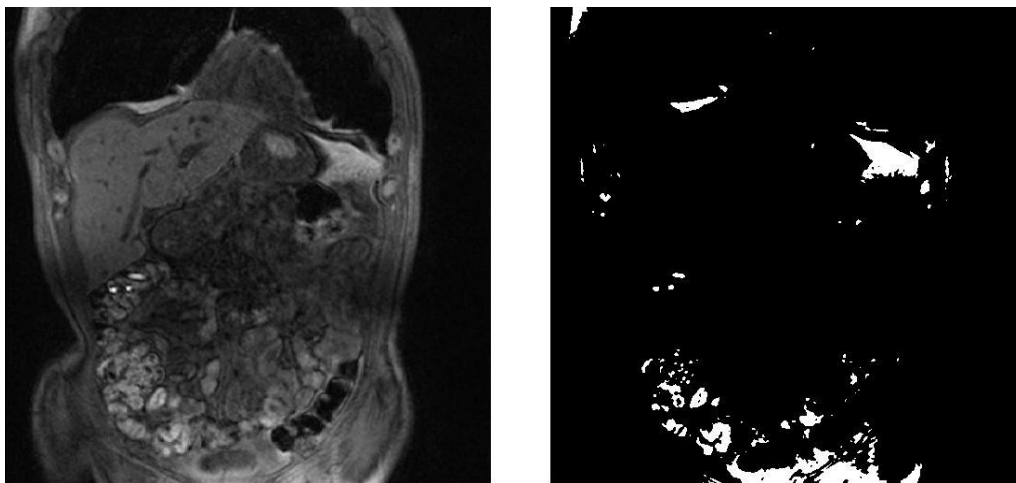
Original and thresholded T1-weighted MR-image. Three capsules are located in the middle-left area of the slice. They are properly segmented but a lot of high-intensity artifacts (= false positives) are remaining when using the current threshold value).
